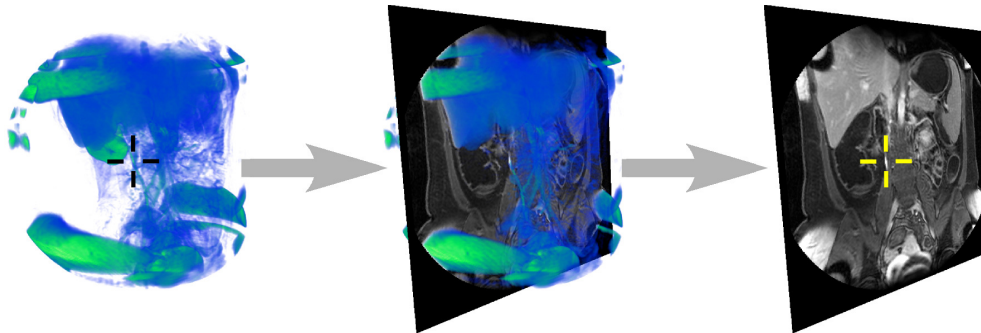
Perception-oriented picking in DVR applied to abdominal magnetic resonance imaging (MRI) scan. The picked position is used for selecting a slice depicting the picked feature (vessel). The position is marked with crosshairs in the left and right image.
